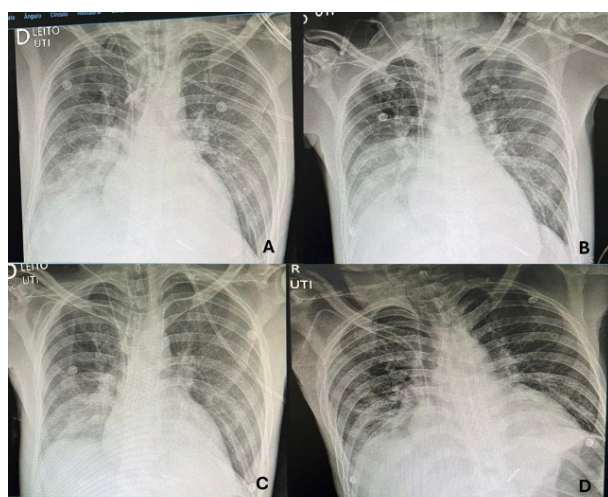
Sequence of chest X-rays showing improvement in the patient's clinical condition.
